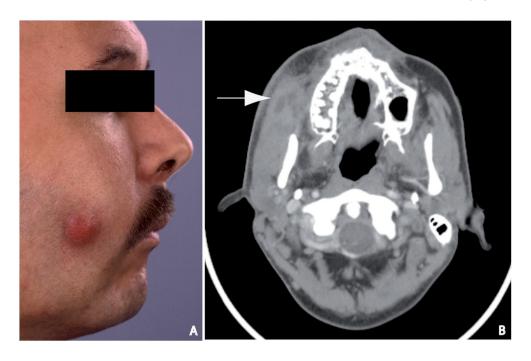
(A) Clinical presentation with a prominent red-to-purple skin nodule on the right cheek. (B) Cranial computed tomography (CT) scan showing a tumour over the right masseter muscle (arrow).
